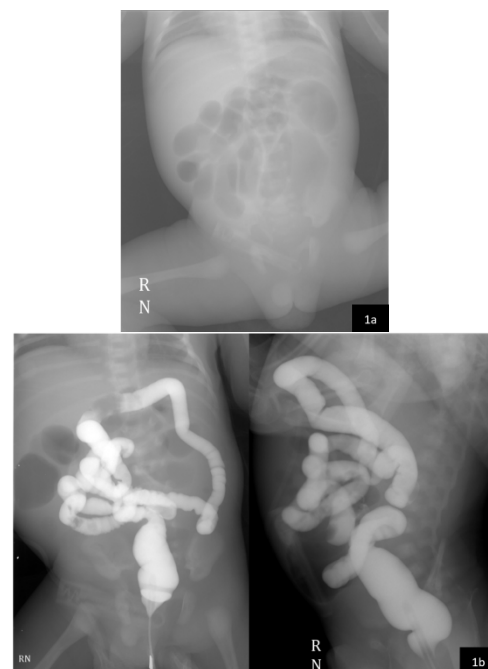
Abdominal radiograph showed multiple dilated intestinal loops with minimal of gas on colon and rectum. (1b). Contrast enema demonstrated microcolon with contrast flow filled rectum, sigmoid colon, descending colon, transverse colon, ascending colon and partially distal ileum.
